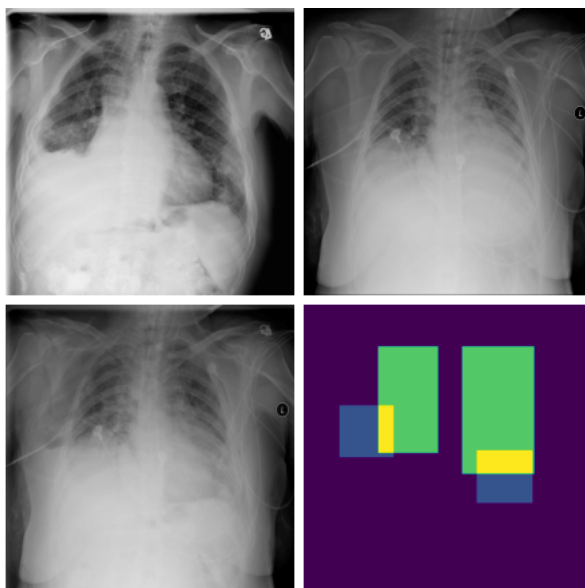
Example of mix-up generated images. In the first row there original chest x-rays, in the bottom left there is the result of mix-up augmentation and in the bottom right the corresponding mask. (Image credit: [112])
